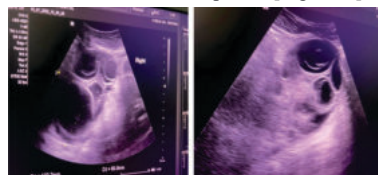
2 Ultrasound Image Of The Study Patient
